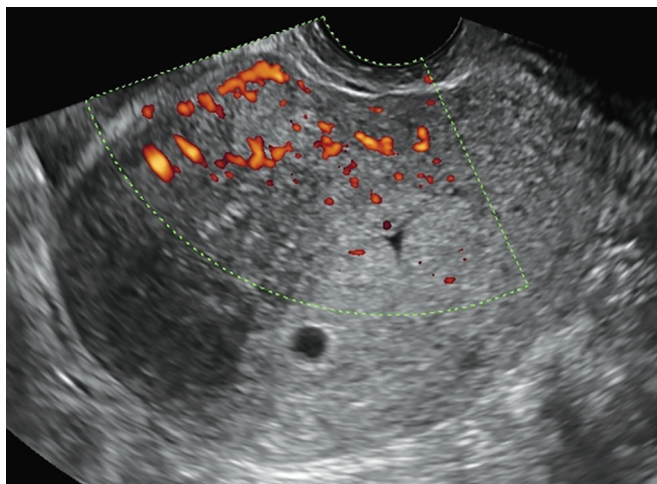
Transvaginal color Doppler scan of the patient with adenomyosis. Asymmetrical anterior myometrial thickening, increased vascularity in the anterior uterine wall, loss of endometrial–myometrial interface, and solitary myometrial cyst posteriorly
